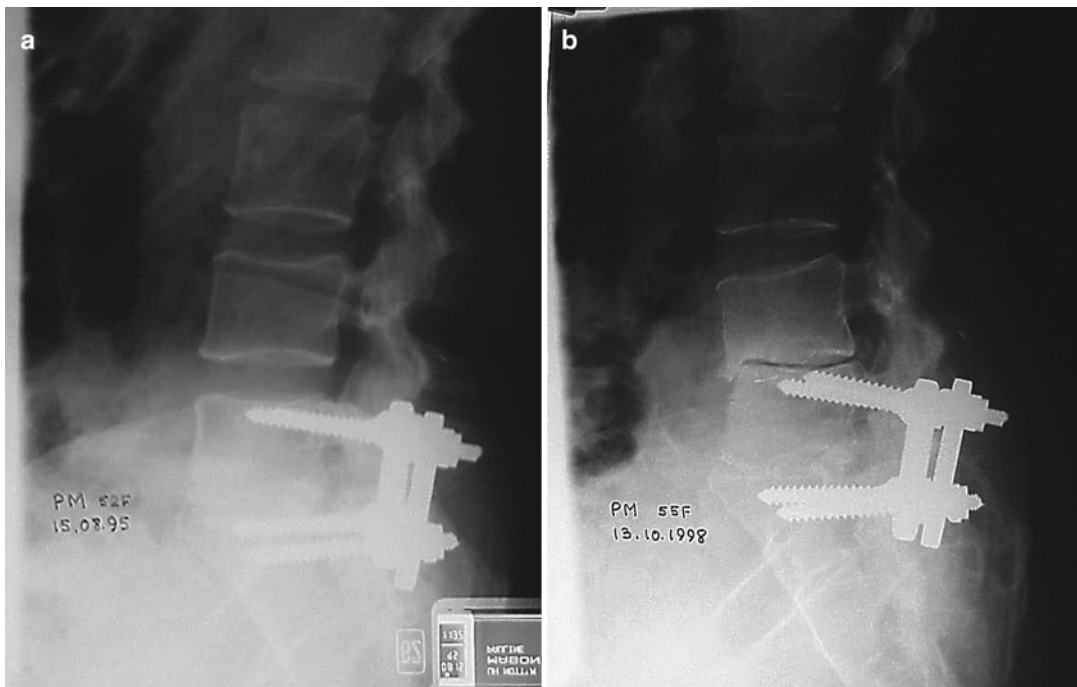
(a) Lateral radiograph of an instrumented fusion; (b) 3 years after fusion demonstrate adjacent segment degeneration of the level above the instrumented fusion
